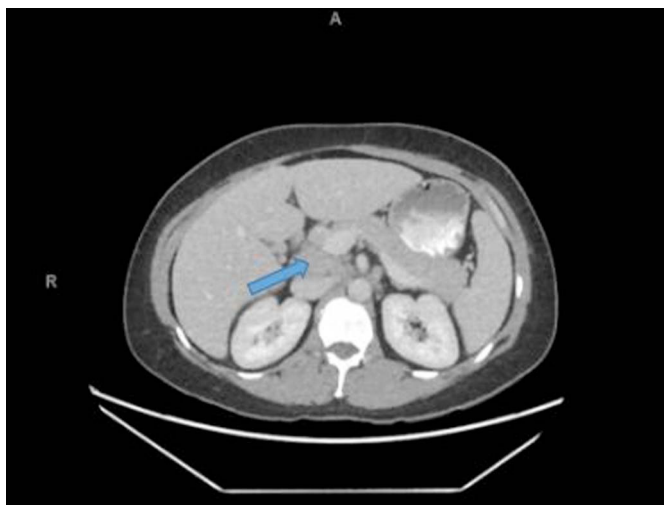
Abdominal computed tomography with an arrow pointing to the enlarged portacaval lymph node.
